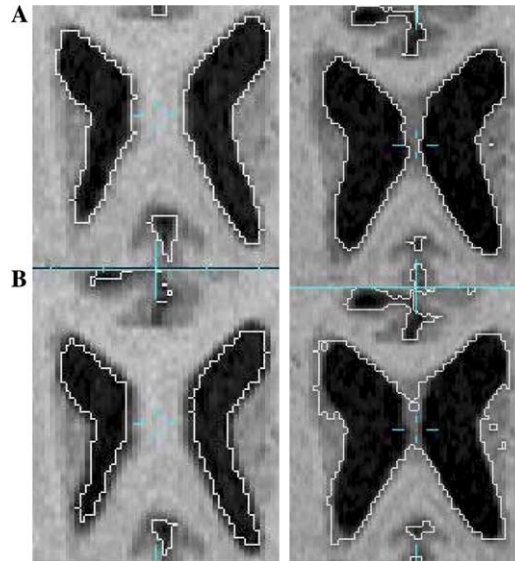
Overlay of tissue-CSF contour onto trans-axial MRI slices showing the effects of the two proposed modifications to the multi-phase level set model (left column) and the effect of different temporal-spatial smoothness constraints (right column). In the left column we show results using our modified model (A) and the original, 4D multi-phase level set model (B). Note that the original formulation undersegments the CSF region of the ventricles at this time point, whereas our proposed model extracts a much more accurate tissue-CSF boundary. In the right column we show results using our modified model with equal spatial-temporal weights (B) and with $w_t = 8$ (A). Note particularly the errors in the contour location both in the mid-line and the left ventricular contour.
